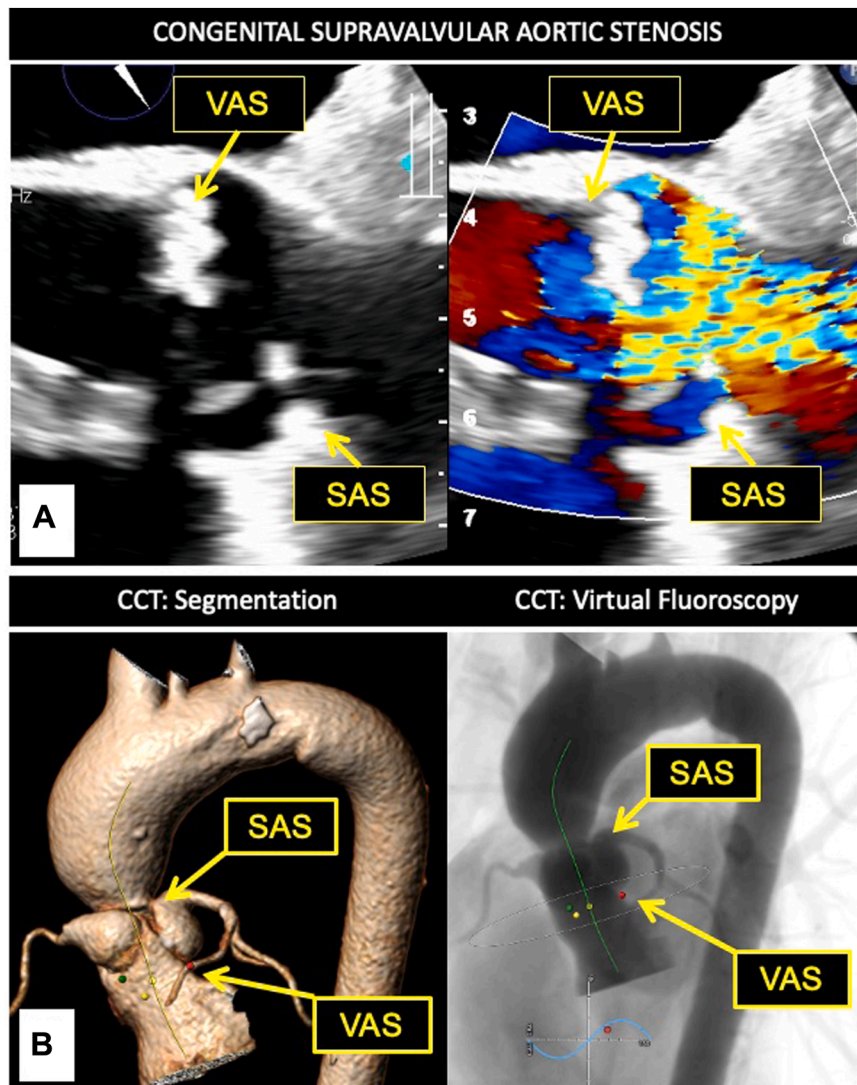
(A) Two-dimensional TEE (*top*), midesophageal zoomed long-axis (125°) systolic view centered on the AV without (*left*) and with (*right*) color flow Doppler of the congenital SAS and valvular aortic stenosis (VAS), demonstrates the thick, calcified AV with reduced opening and the accelerated Doppler flow across the serial stenoses. (B) CCT (*bottom*), three-dimensional volume-rendered reconstruction (*left*) and virtual fluoroscopy (*right*), sagittal display, demonstrates the VAS and congenital SAS and their relationship to the coronary ostia.
